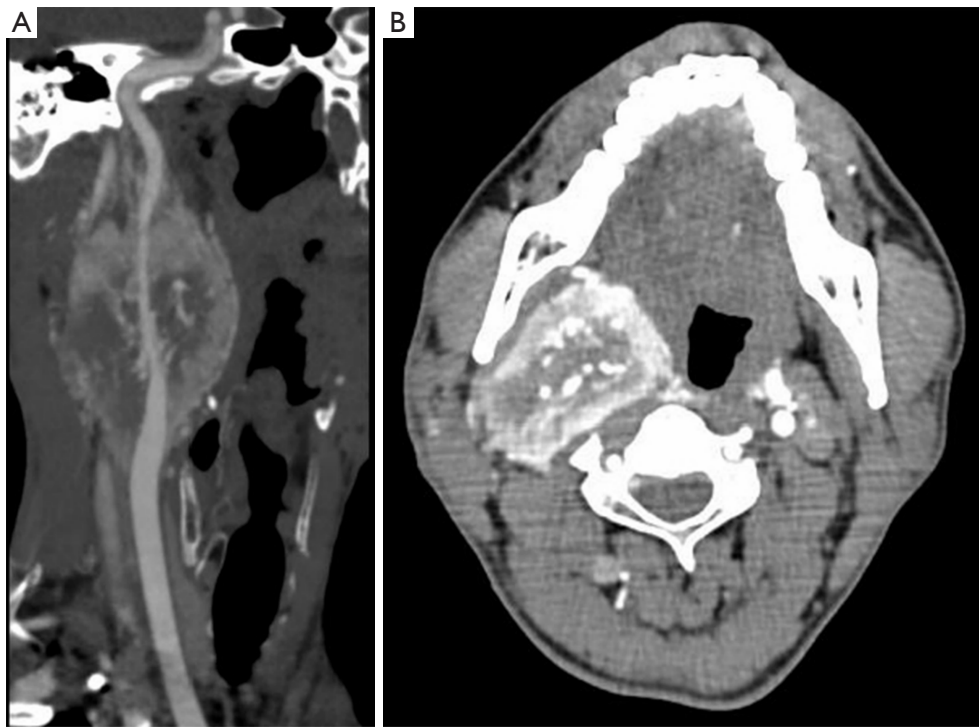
A 3D reconstruction of vessels and the contrast-enhanced CT finding. (A) A 3D reconstruction of the cervical vessels showed a mass encasing the right distal CCA, the carotid bifurcation, ICA, and ECA. (B) Contrast-enhanced CT showed a highly vascularized lesion on the right side of the upper neck. 3D, 3-dimensional; CT, computed tomography; CCA, common carotid artery; ICA, the proximal internal carotid artery; ECA, the external carotid artery.
